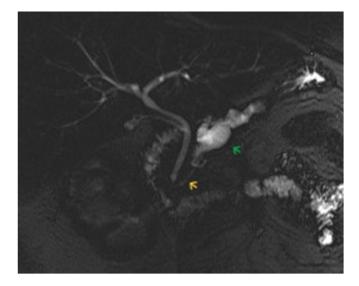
Magnetic resonance imaging demonstrating a diffusely dilated pancreatic duct in the body and tail of the pancreas (*green arrow*). The pancreatic duct in the pancreatic head appears to be nondilated (*yellow arrow*).
